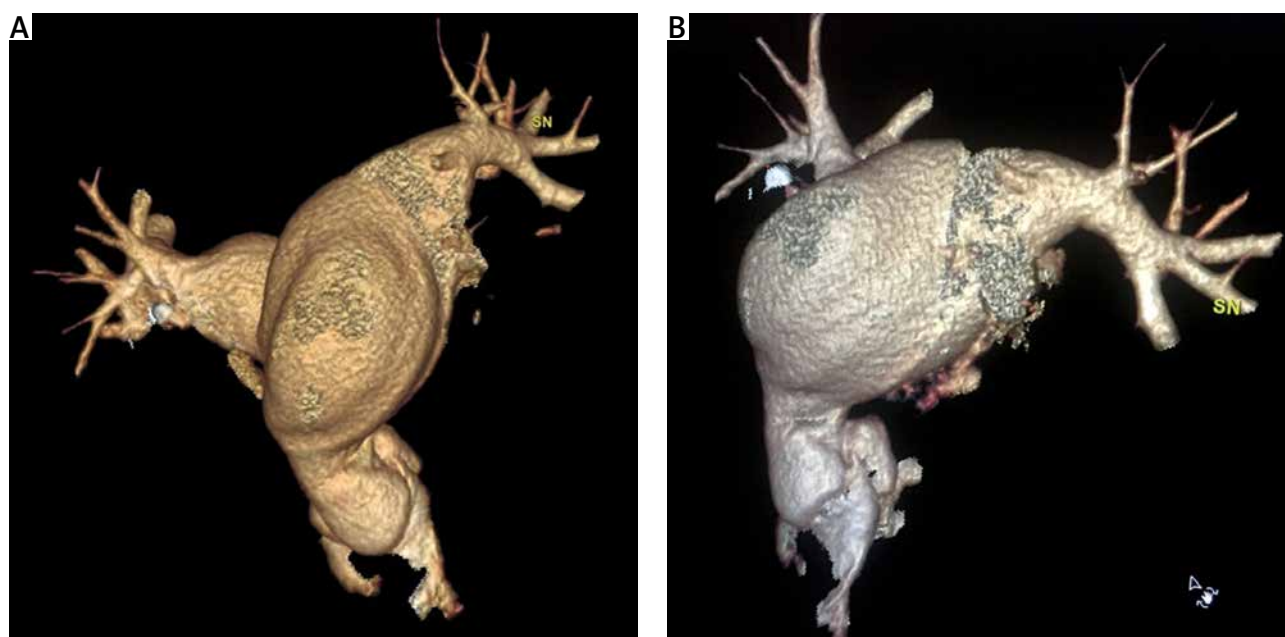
A, B – Three-dimensional computed tomography reconstruction
